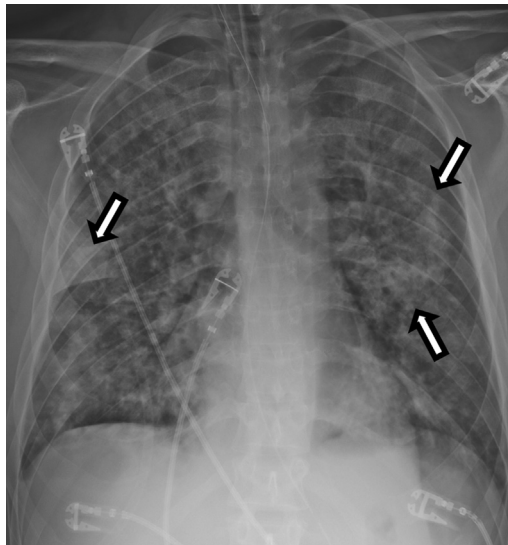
Respiratory syncytial virus in a 29-year-old man with acute myelogenous leukemia status poststem cell transplant. Frontal chest radiograph demonstrates bilateral reticulonodular opacities and bronchial wall thickening compatible suggesting bronchiolitis and bronchitis. There are more focal airspace opacities in the right mid and lower lung, and left perihilar lung (*arrows*) likely representing associated pneumonia.
